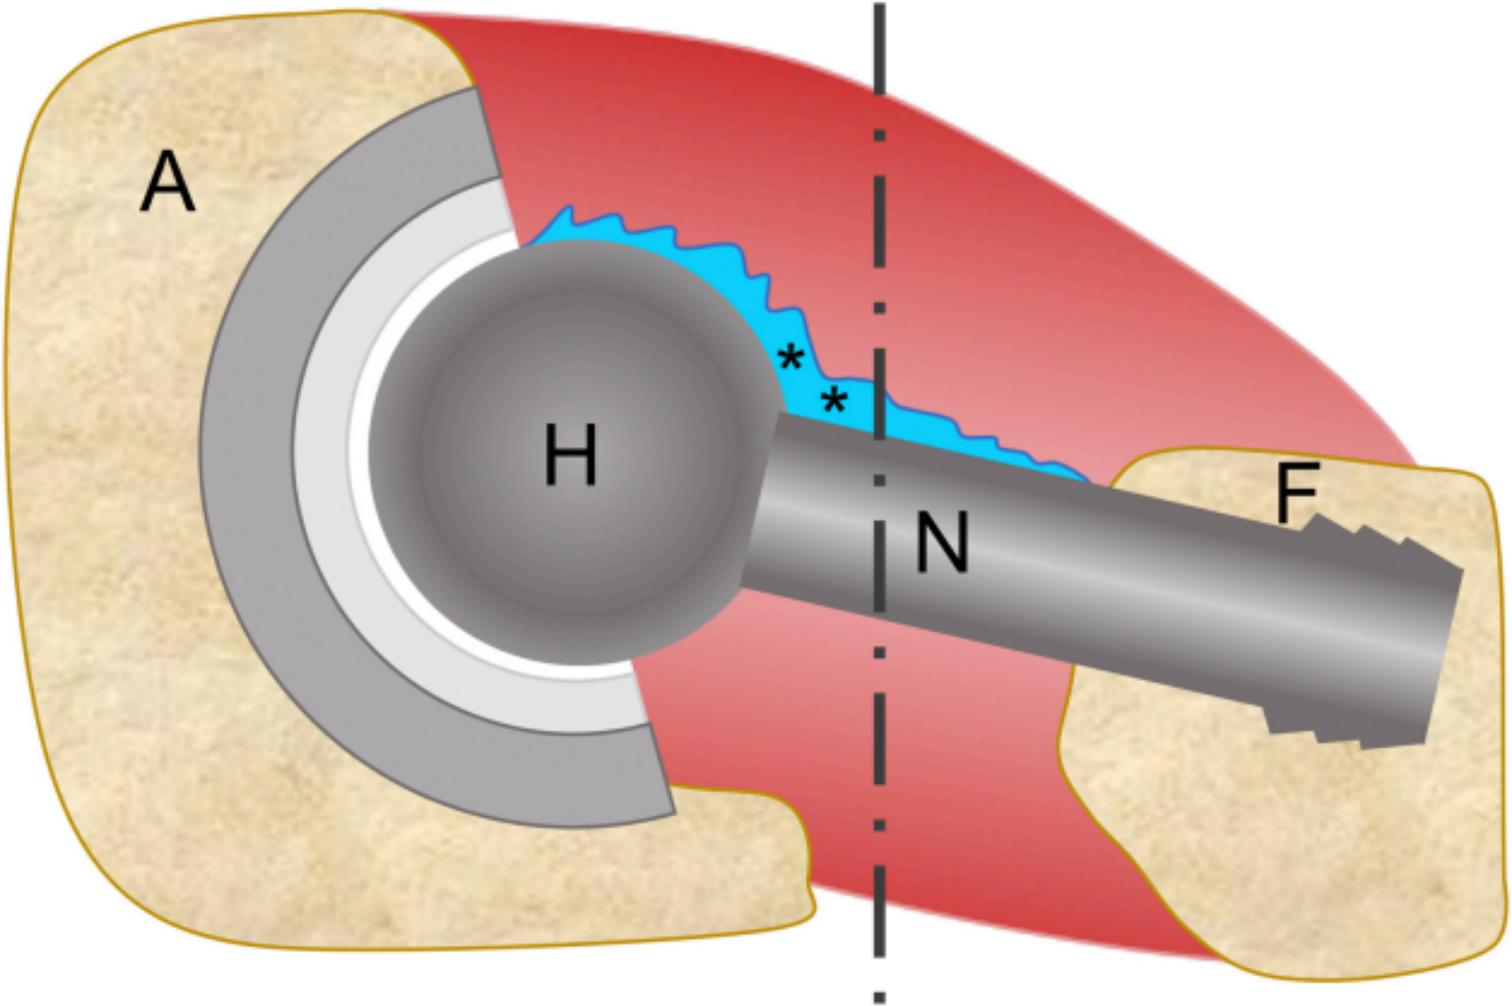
Sagittal oblique ultrasound image of a hip arthroplasty biopsy in a 71-year-old patient being studied for potential infection. The hip of this patient was completely dry as evaluated on pre-procedure MRI (not shown). The anatomy of the replaced hip can be seen. A=acetabulum; H=femoral head; N=neck of the prosthesis, with arrow indicating the ultrasound interface; F=femoral bone, with thick arrow indicating the ultrasound interface; dashed and dotted line=section where the axial scan is obtained; *=synovial tissue.
